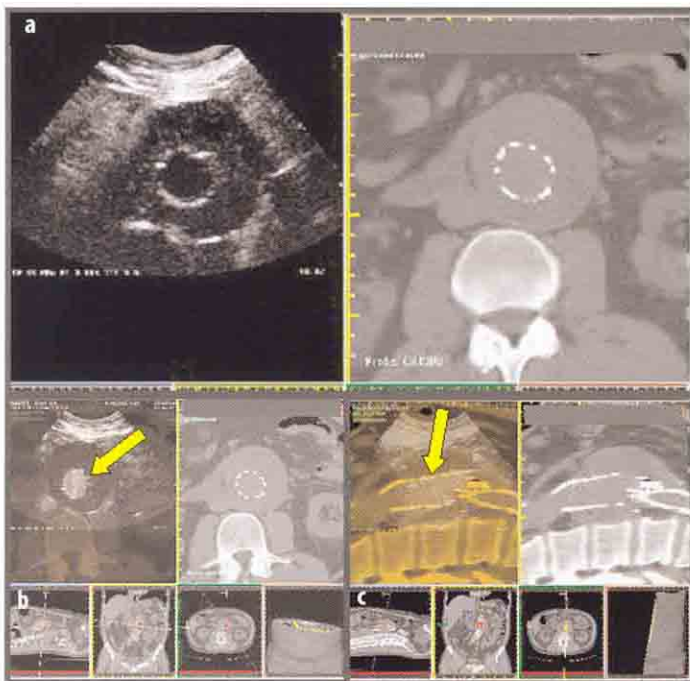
Abdominal aortic aneurysm and Fusion Imaging CEUS/CT. a CEUS transversal baseline scan and analogous transversal baseline CT. b Transversal (b) and longitudinal (c) CEUS scan after contrast administration; prosthesis is normally patent (yellow arrow) without any signs of endoleak; in the left of the screen there are analogous transversal and longitudinal CT baseline scans
